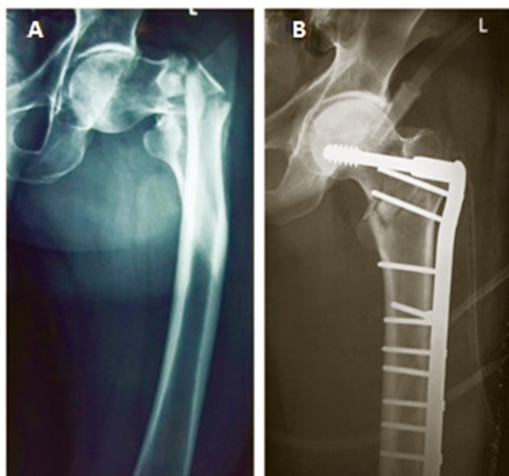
Pre-op & Post-op x-rays of 49 Years Old Female Patient (A, B).
